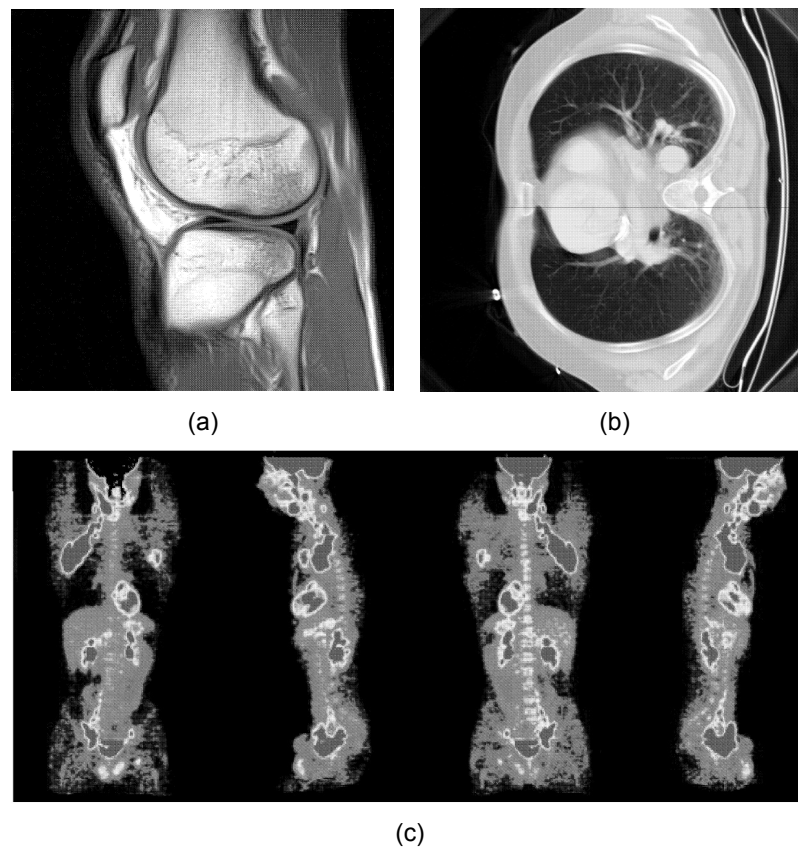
Examples of medical images (a) Sagittal MRI knee image (b) Transaxial CT lung slice (c) PET scan for lymphoma [22].
